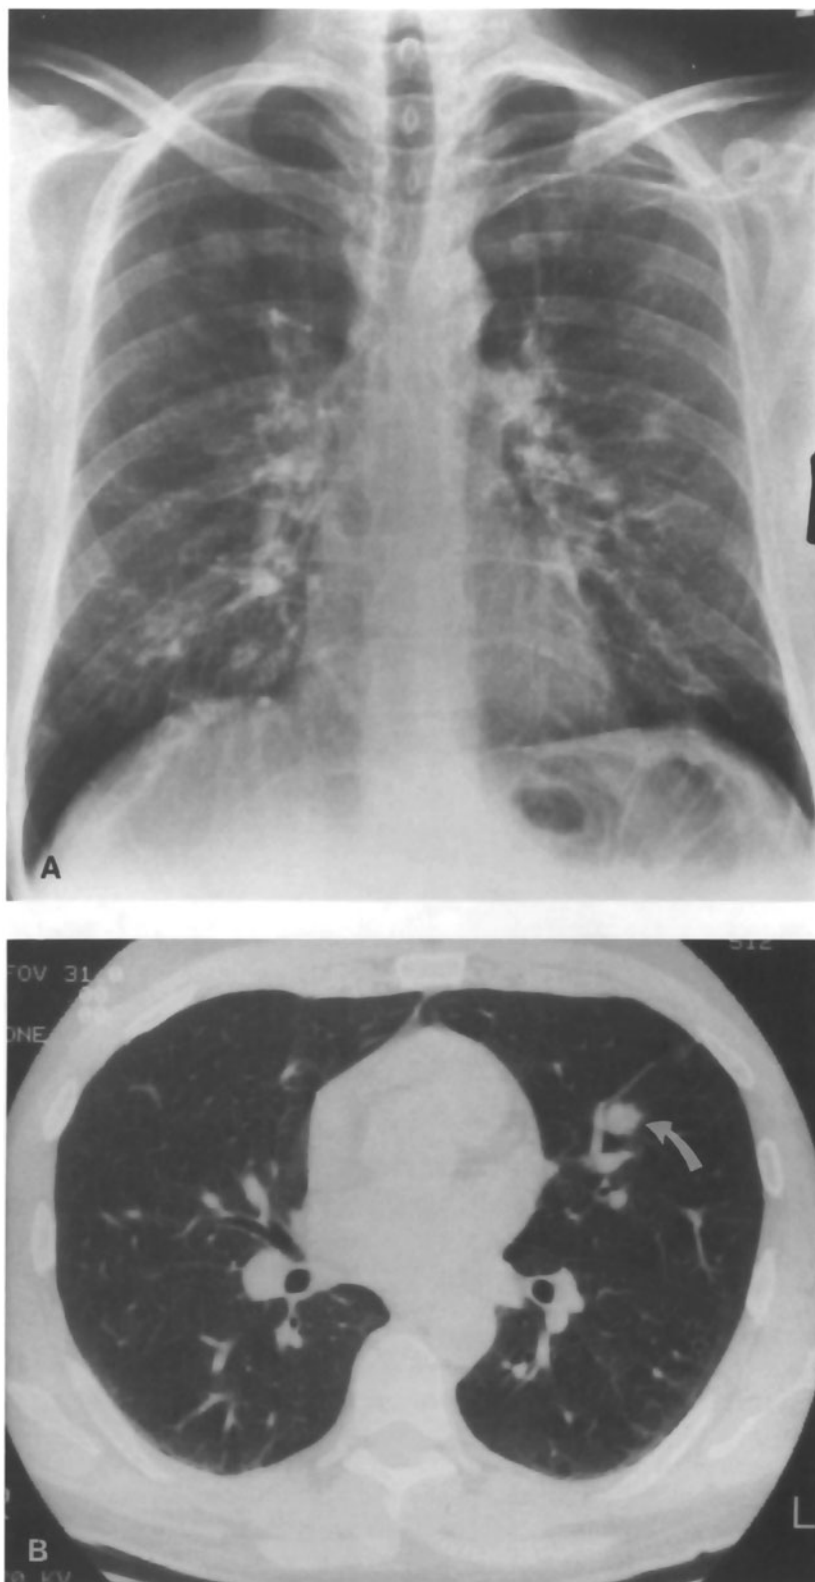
Kaposi's sarcoma. (A) Subtle multifocal peripheral opacities are suggested by a chest radiography in an AIDS patient with mucosal and skin lesions of Kaposi's sarcoma. (B) A single section from a CT scan shows one of many nodular lesions (↔) characteristic of Kaposi's sarcoma.
